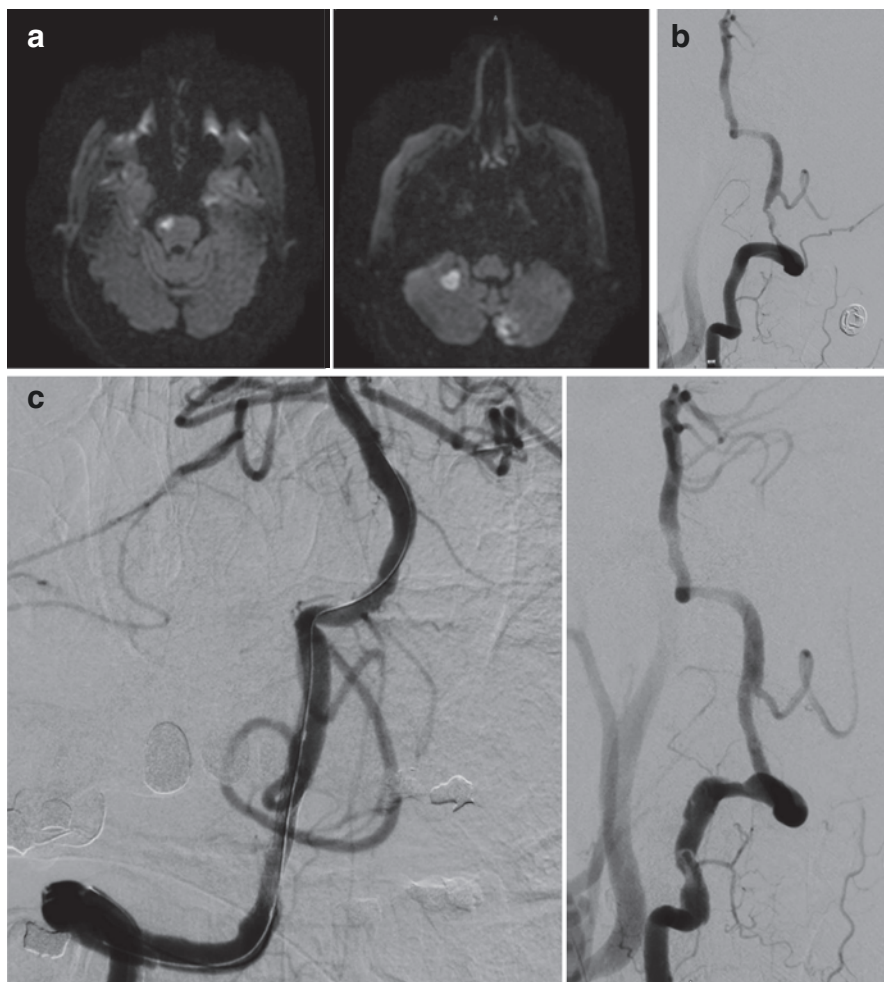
Right vertebral artery (VA) ostial stenosis. A 72-year-old man presented with ataxia of his left upper and lower extremities. Magnetic resonance imaging (MRI) demonstrated left cerebellar infarcts (a). Diagnostic catheter angiography revealed >80% ostial stenosis of the right VA (b). The left VA was chronically occluded at its origin from the subclavian artery. A balloon-mounted stent was deployed across the right VA stenosis (c). Subsequent injections demonstrated near-complete resolution of the stenosis with improved flow across the right vertebral artery ostium (d)
